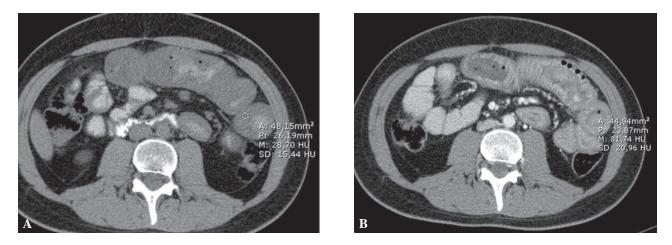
A 24 year-old male with T-cell lymphoma featuring intestinal presentation (patient #5 of Table 2). (A) Axial pre- and (B) post-contrast CT images reveal a thickened jejunal wall (pre-contrast value ; +28 HU, post-contrast value ; +81 HU).
